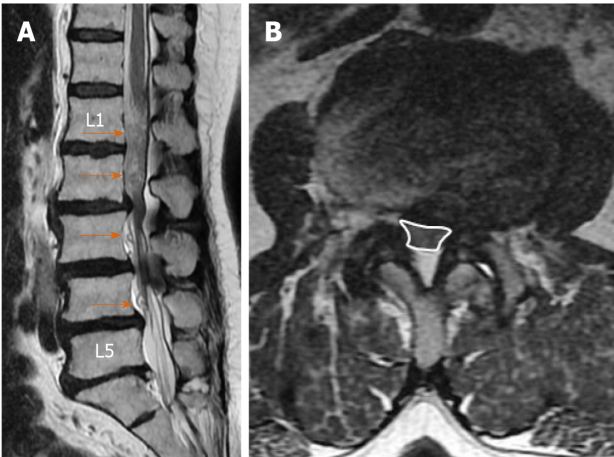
Seventy-one-year-old female patient with lumbar spondylosis. A: Redundant nerve roots (arrows) secondary to the stenosis at both the superior and inferior of the stenosis at the L2-L3 level, which are more prominent at the superior, are shown; B: On the axial T2-weighted image, the cross-sectional area of the dural sac was 41.60 mm² at the stenosis level (L2-L3).
